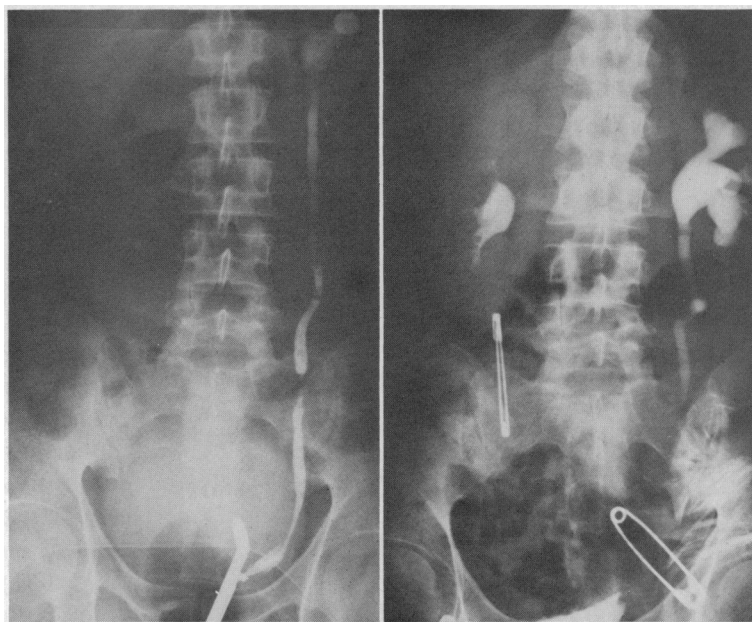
Left, a midureteral obstruction was demonstrated radiographically in 1971. Right, fourteen days after resection of a segment of ureter and end-to-end ureteroureterostomy, an excretory urogram showed midureteral obstruction.
